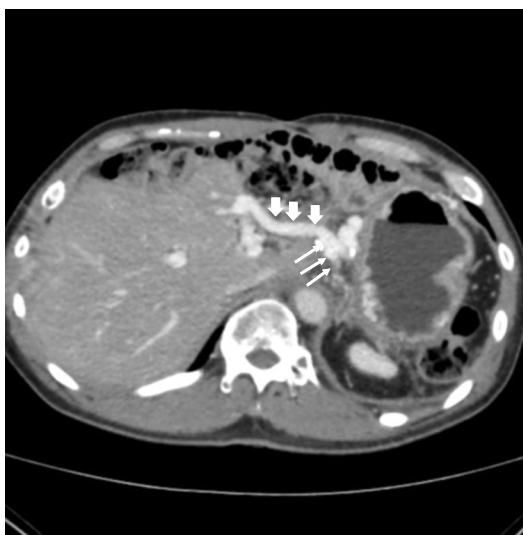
Follow-up computed tomography after two years showed complete patency of the great saphenous vein graft (thick arrows) and coronary vein (thin arrows).
